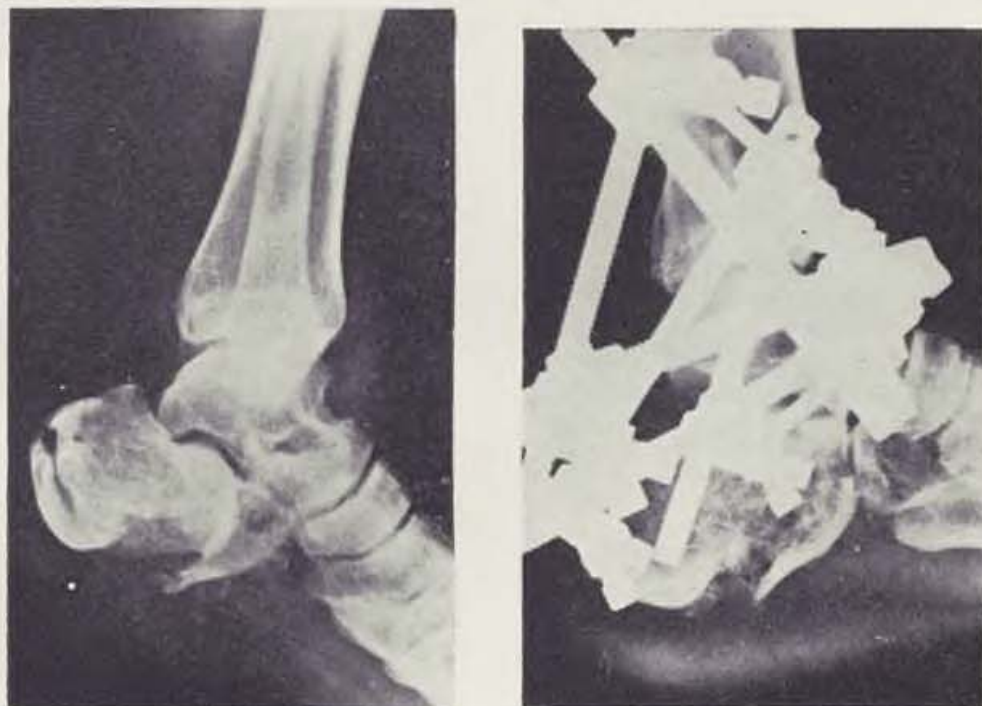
X-ray picture — dislocation open fracture of heel bone. — Fig. 4. X-ray picture — state after reposition and fixation with fixateur externe.
